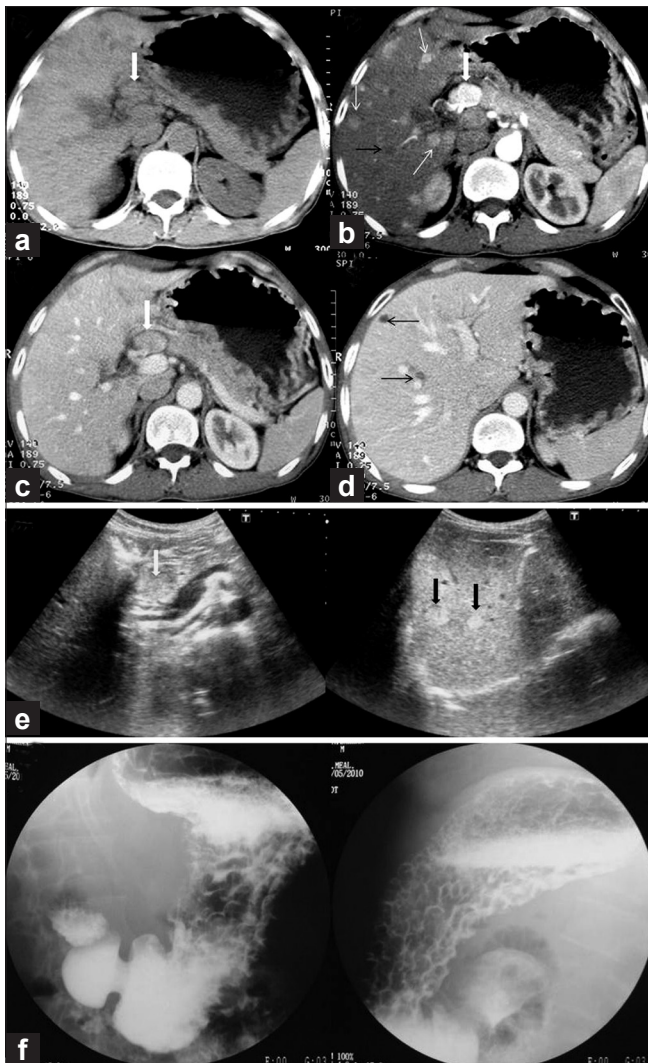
Functioning islet cell tumor: Gastrinoma in a 25-year-old male patient with Zollinger–Ellison syndrome (ZES). Axial plain (a) and dual-phase contrast-enhanced CT abdomen obtained in arterial (b) and portal venous (c, d) phase shows a small, well-defined mass of 1 × 0.5 cm size in the gastric triangle (thick vertical white arrow). The lesion is homogenous and hypodense on non-contrast CT, shows marked homogenous contrast enhancement in arterial phase image (suggesting hypervascular nature) and washout of contrast in portal venous phase. Majority of liver metastases from the tumor are hypervascular, appearing as homogenous hyperenhancing foci (thin white arrow) in arterial phase image, while a few are hypovascular appearing as non-enhancing foci both on arterial and portal venous phase images (thin black arrow). Due to hypervascular nature, both the tumor (thick vertical white arrow) and metastases (thick vertical black arrow) appear echogenic on ultrasound (e). Double-contrast barium meal (f) of the same patient demonstrates thickened gastric folds. Endoscopy revealed peptic ulceration of upper gastrointestinal tract. Patient also had hypergastrinemia
